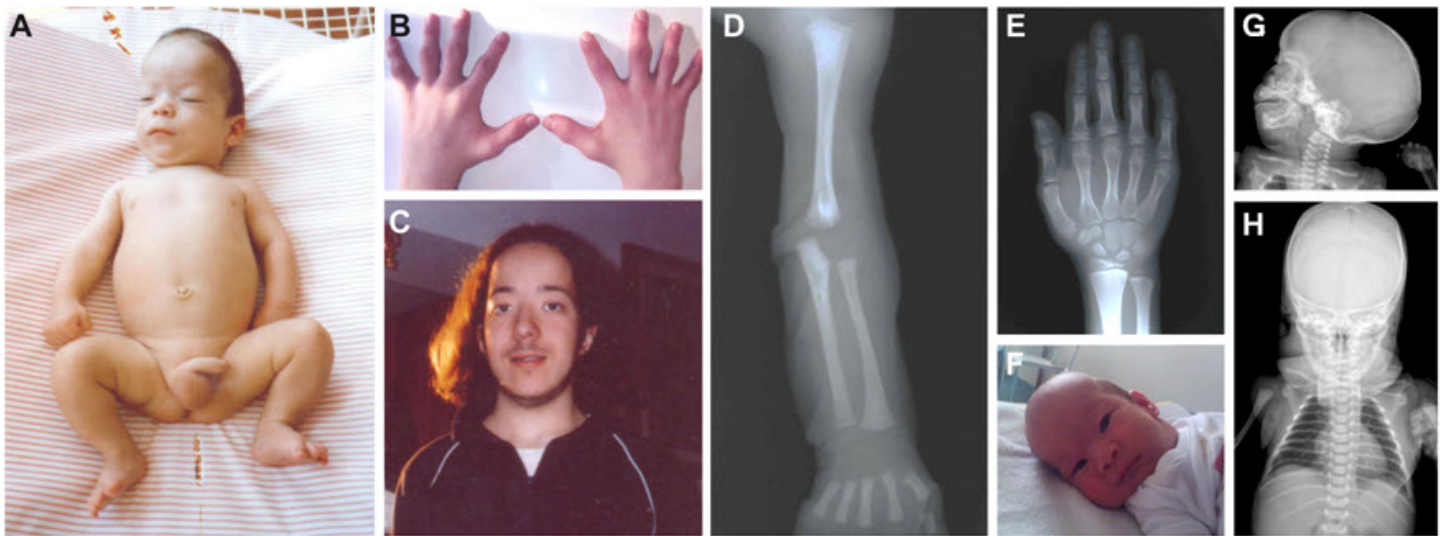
Clinical and radiographic features of cranioectodermal dysplasia (CED)
